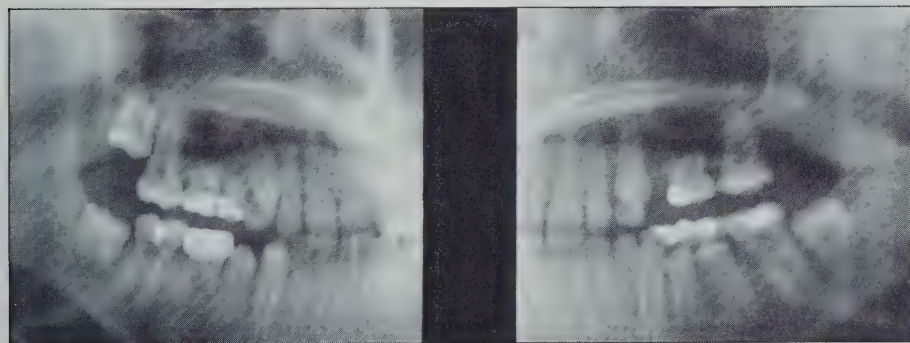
Panoramic radiograph of the patient's brother (left to right). Missing 10 permanent teeth.
